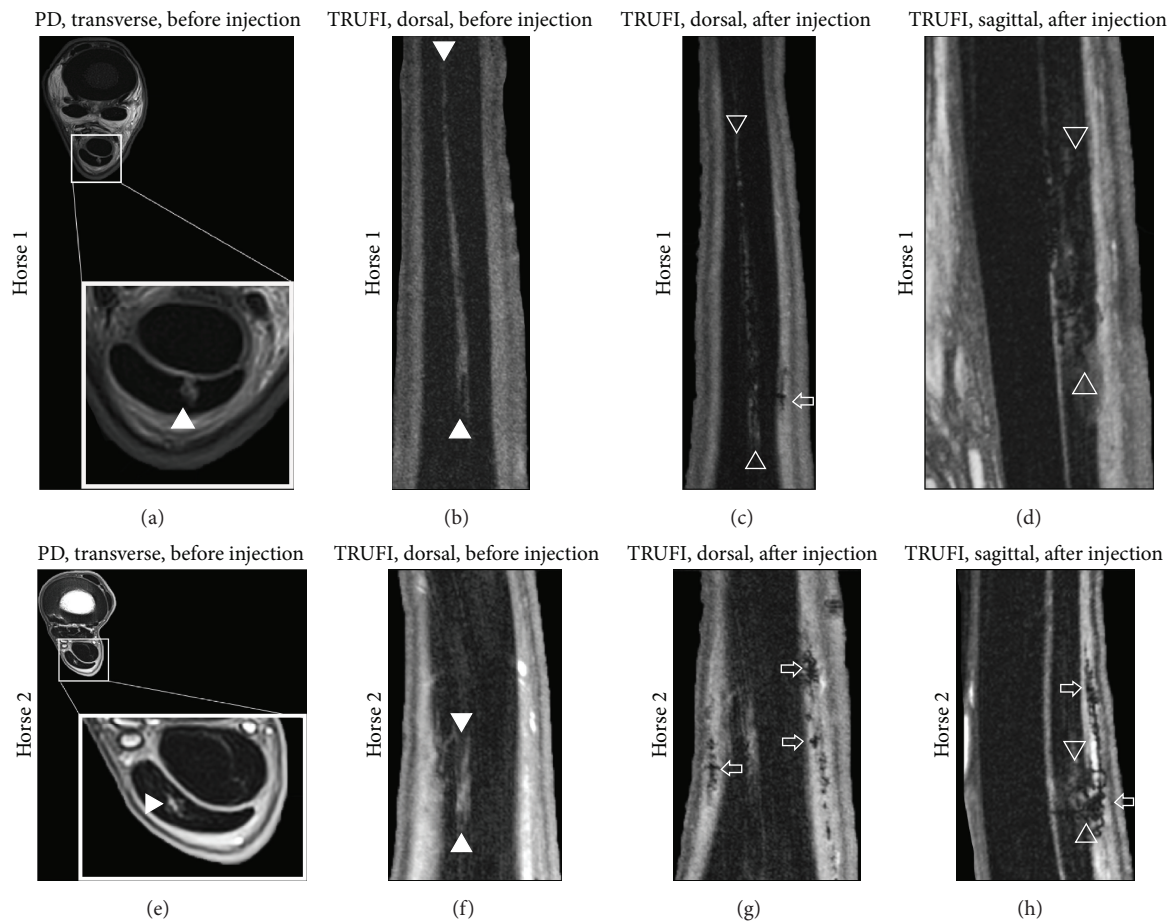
MRI of iatrogenic, SDFT lesions before (a, b, e, f) and after (c, d, g, h) injection of SPIO-treated cells. Solid arrowheads delineate the tendon lesion in preinjection images. Open arrowheads indicate SPIO-treated cells within the tendon lesion after injection. The SPIO-treated cells are seen as small, heterogeneous clusters of dark signal. The open, horizontal arrows indicate SPIO-treated cells distributed throughout the tissue layers surrounding the tendon.
